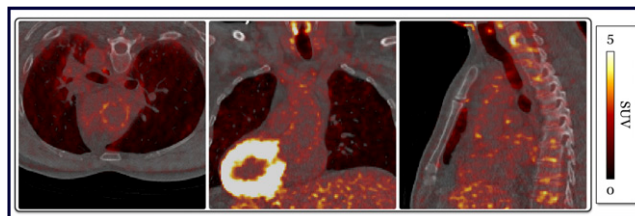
^{18}F -FDG PET imaging of vascular and systemic inflammation in patients with posttraumatic stress disorder (PTSD). ^{18}F -FDG signal in the ascending aorta was quantified on images acquired at 90 minutes and was expressed as target-to-background ratio by normalizing average maximal standardized uptake values measured on consecutive slices, with blood pool activity (SUV_{mean}) measured in the superior vena cava. On the same late images, ^{18}F -FDG uptake was quantified in the spleen, bone marrow and brain region of amygdala and expressed as SUV_{mean} . No measurements of vascular or systemic inflammation differentiated PTSD and control subjects, as assessed by ^{18}F -FDG PET imaging.
